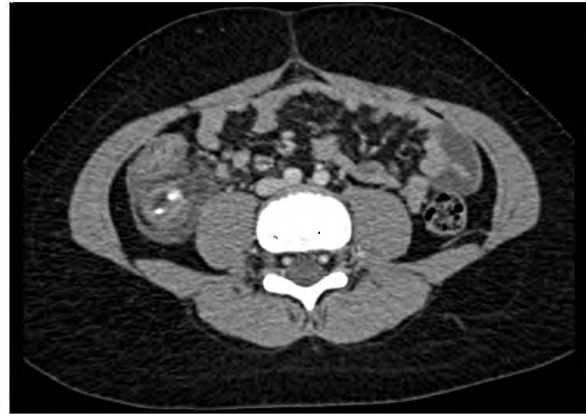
Axial contrast enhanced CT image showing Enlargement of the appendix (18 mm) Increased enhancement of appendicial wall on postcontrast images Two millimetric appendicoliths in the lumen of the appendix.
